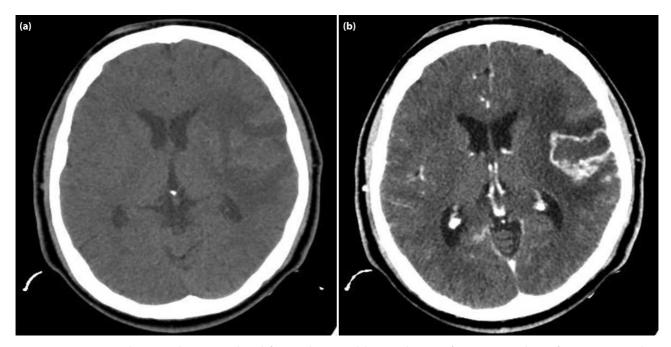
Brain computed tomography (CT) reveals (a) left parietal mass, and (b) rim-enhancing after contrast medium infusion. Extensive white matter edema.
